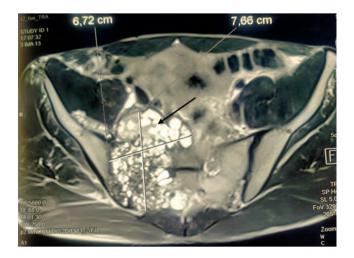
Axial section of MRI T2 sequence showing a mass occupying the right sacrum measuring 80×70 mm in axial and 100 mm in height, this mass is in hypersignal T2 with a multivesicular aspect (Black arrow).
